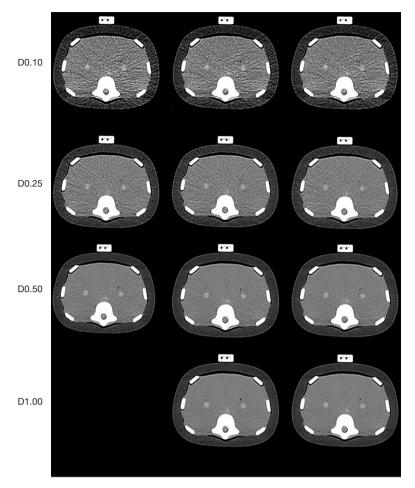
CT images at different ADMIRE levels and different dose levels, corresponding to *Table S2*. The two operators chose in consensus: D1.00: ADMIRE 2; D0.50: ADMIRE 3; D0.25: ADMIRE 4; D0.10: ADMIRE 5. CT, computed tomography; ADMIRE, advanced model-based iterative reconstruction.
